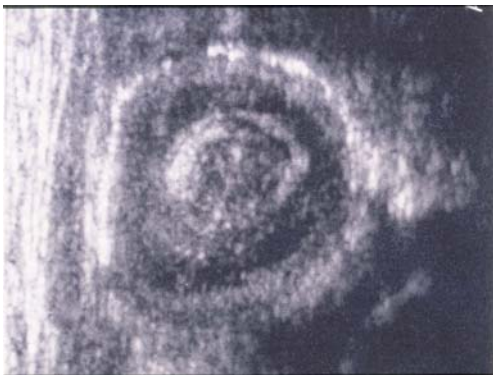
Ultrasound scan showing the target sign of the intussusception.
